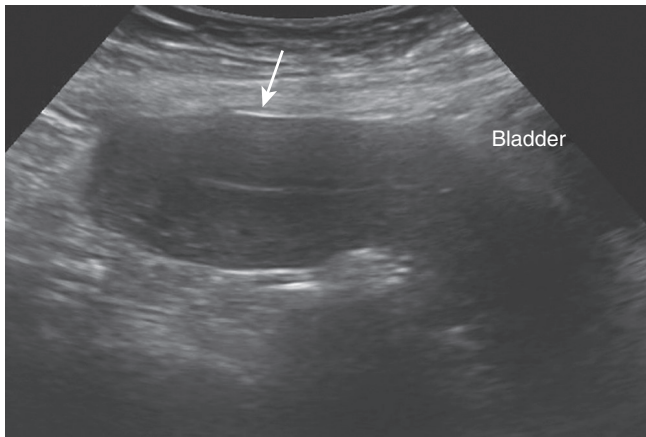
A transvaginal approach to assessment of the uterus and adnexa is preferred, yet a transabdominal scan may be required for imaging of pelvic structures beyond the focal length of the probe, and/or out of the pelvis, such as in the case of this uterus adherent to the anterior abdominal wall secondary to prior uterine surgery. Indications the uterus may be adherent out of the pelvis include the fundal apex noted beyond the focal range of the vaginal probe, a “flattened” uterine anterior contour (*arrow*), the absence of small bowel within the anterior cul-de-sac, a bladder that fills but does not expand over the anterior surface of the uterus, and absence of an anterior “sliding” sign on a dynamic bimanual ultrasonographic exam.
